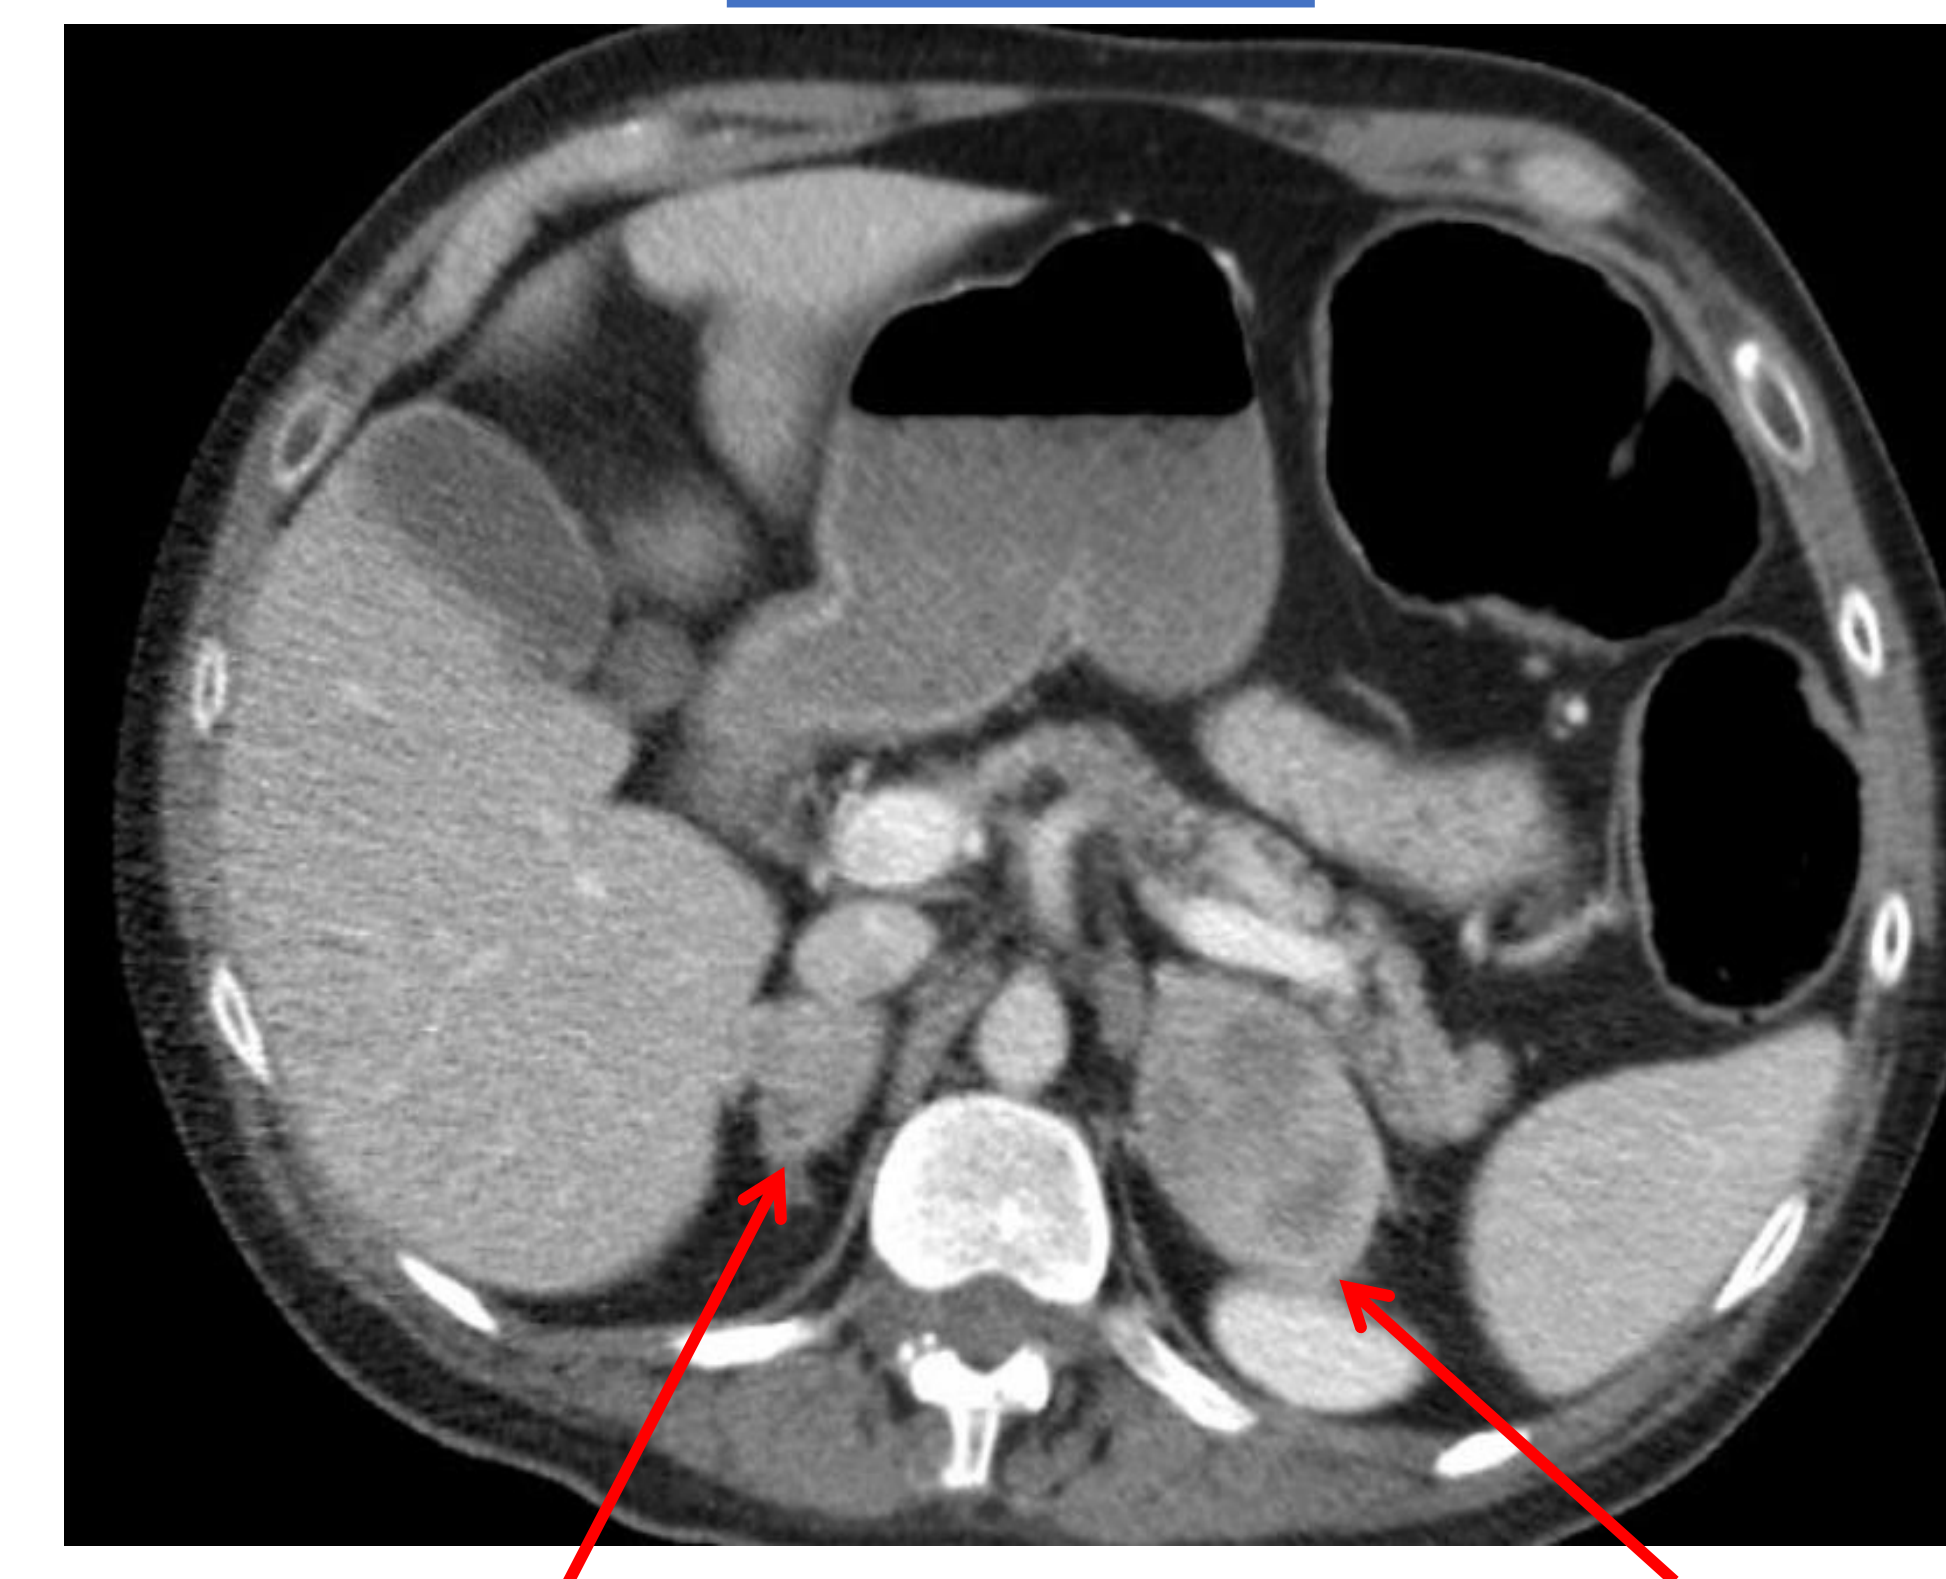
Representative CT slices showing significant decrease in both the left and right adrenal glands. Figure 3 is after approximately 5 months of therapy. Red arrows mark the left and right adrenal glands.
